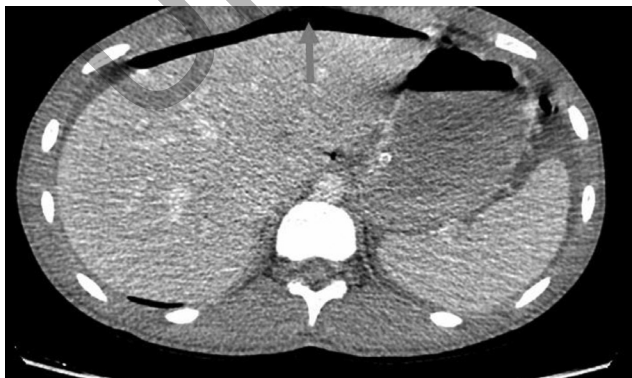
Computed tomography scan showed free air before operation
